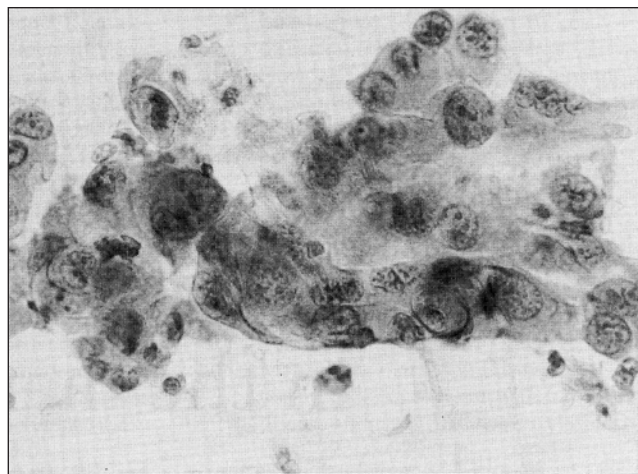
Cytopathology before active specific immunotherapy. Adenocarcinoma cells are consistent with the patient's clinical presentation and computed tomography scan
